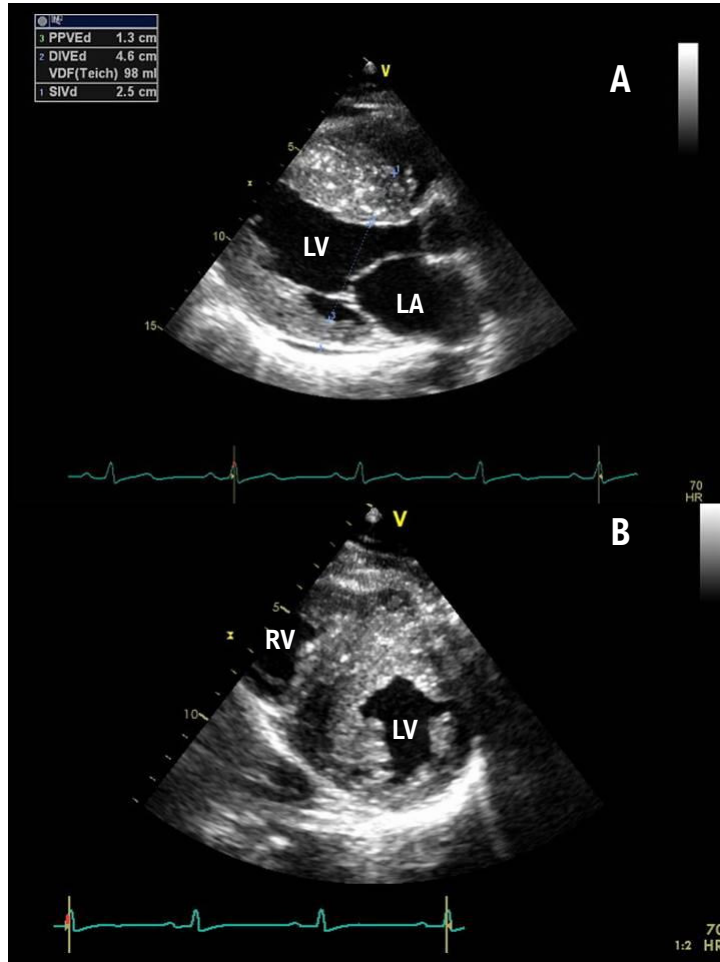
Transthoracic echocardiogram of a patient with HCM showing significant increase in septal wall thickness (25 mm) in the parasternal longitudinal (A) and transverse view at the level of the papillary muscles (B). LA: left atrium; LV: left ventricle; RV: right ventricle. Source: Authors' personal archive.
